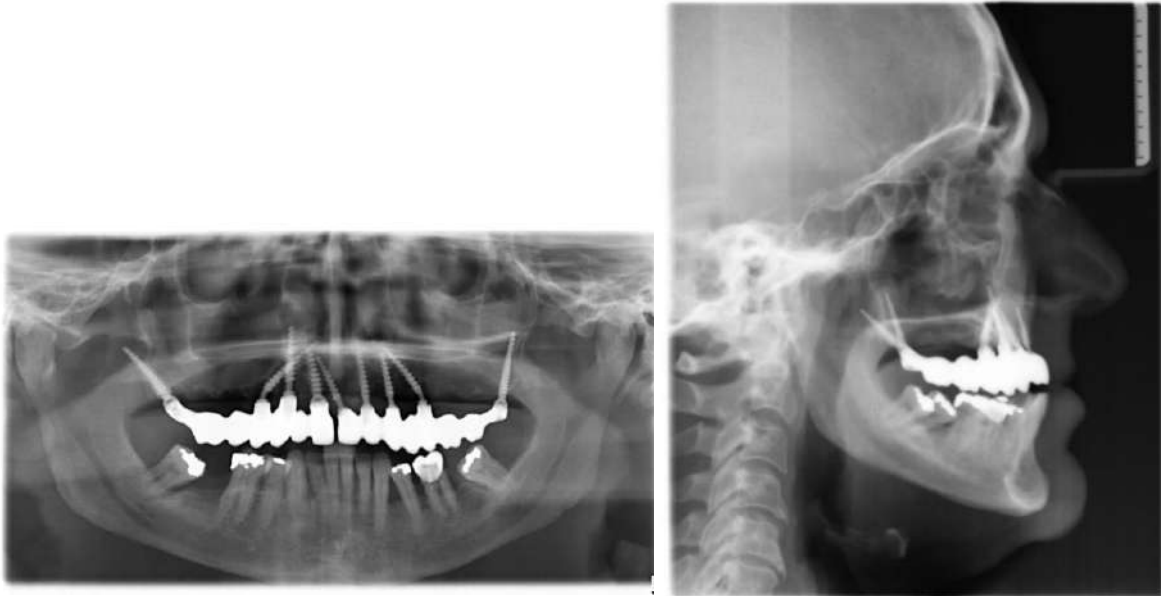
Panoramic radiograph of patient at completion of treatment
